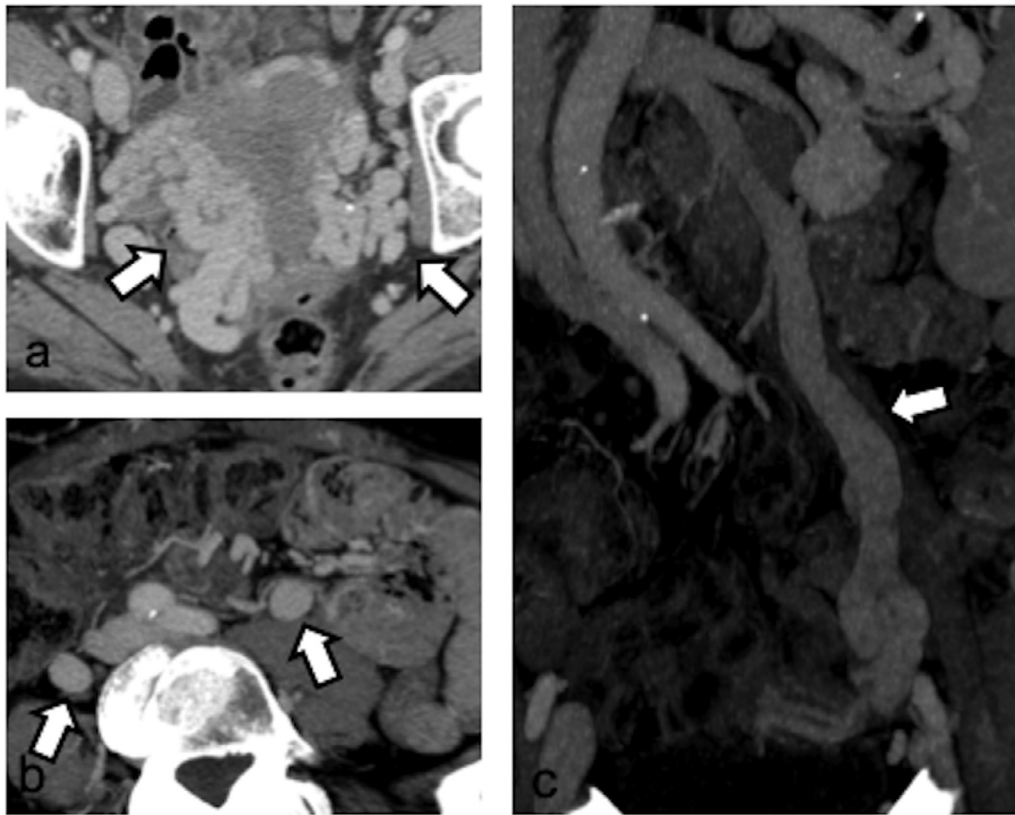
CT imaging shows bilateral ovarian veins Grade III reflux: (a) bilateral parauterine veins dilation (arrows); (b) right and left ovarian veins dilation (arrows); (c) MIP reconstruction showing left ovarian vein dilation (arrow).
